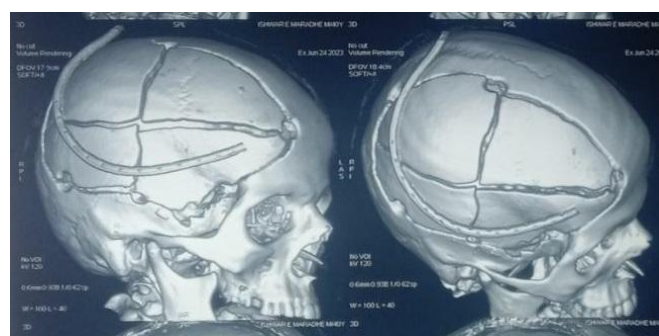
3D reconstruction of post op CT scan
